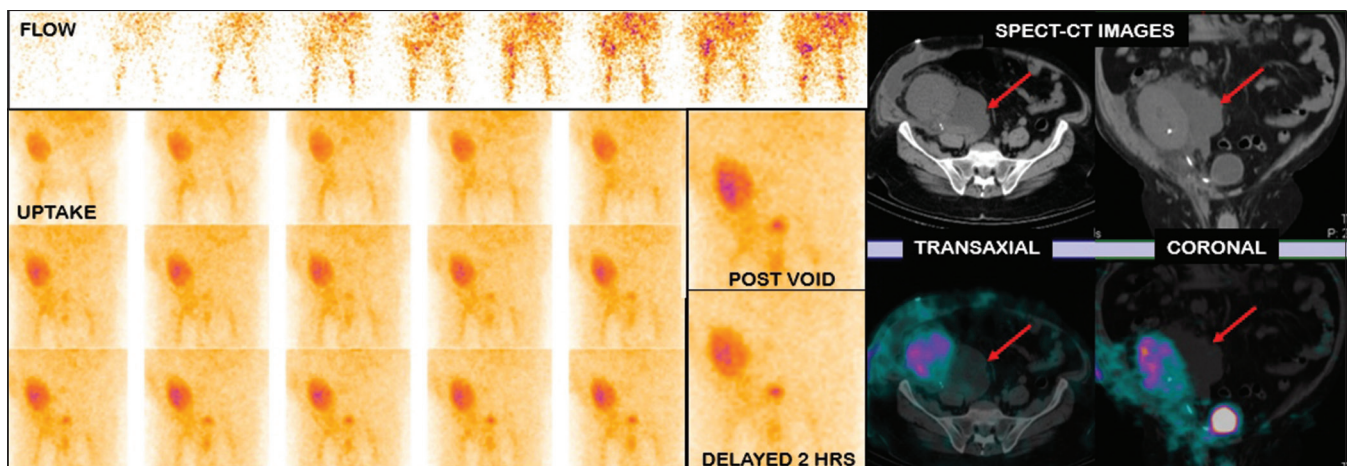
The Technetium-99m DTPA scan for transplant kidney evaluation on postoperative day 60 showed prompt, though, reduced perfusion in flow images showing mild reduced tracer uptake with cortical tracer retention and slow drainage as seen in 2 hours delayed image. No abnormal DTPA collection was noted in the vicinity of the transplant kidney. Single-photon emission computed tomography–computed tomography transaxial and coronal images showed fluid collection medial to the transplant kidney (red arrows) near the surgical staples with no DTPA accumulation ruling out urinoma
